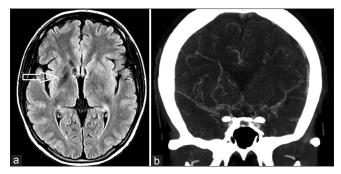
Magnetic resonance imaging of the brain at the time of presentation. Axial fluid-attenuated inversion recovery sequence shows an abnormal signal in the right basal ganglia (a). Computerized tomographic angiography performed on day 2 (b) revealed Moyamoya pattern of collaterals in the regions of both terminal internal carotid arteries and middle cerebral arteries
